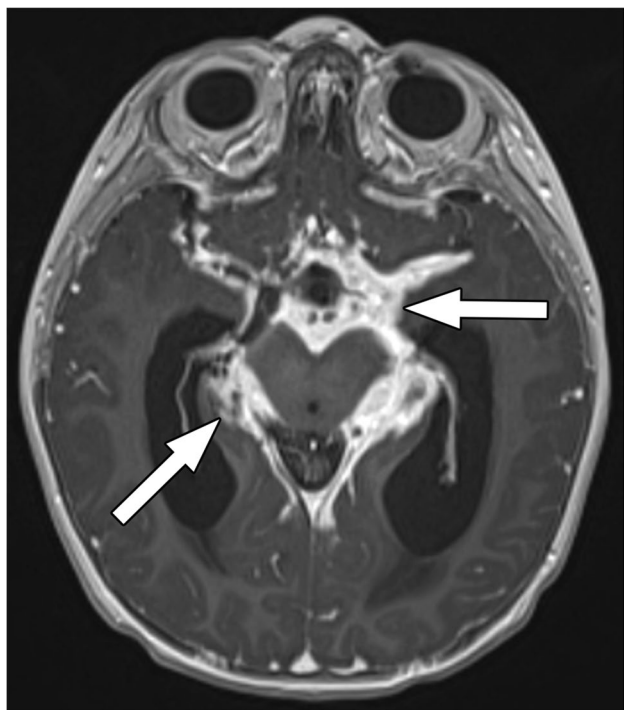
15-month-old boy with meningitis due to disseminated coccidioidomycosis. Axial contrast-enhanced T1-weighted MR image of the brain shows thick, irregular enhancement of the meninges and basal cisterns (arrows). The partially visualized lateral ventricles are dilated due to obstruction of CSF flow
